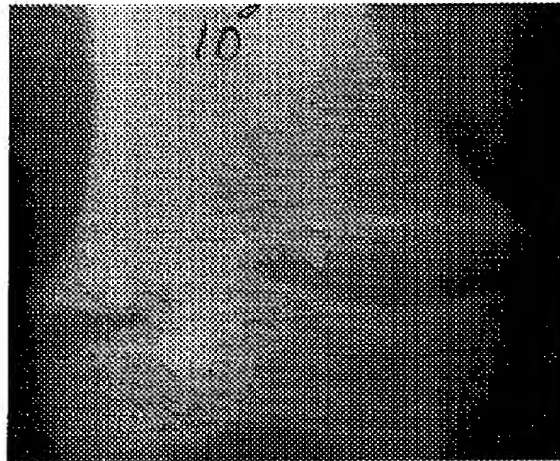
Radiograph of the distal femur in a child with XLH. Note the asymmetry of the severity of the rachitic lesion at the growth plate, with the medial physis being considerably wider and more frayed than the lateral physis.
